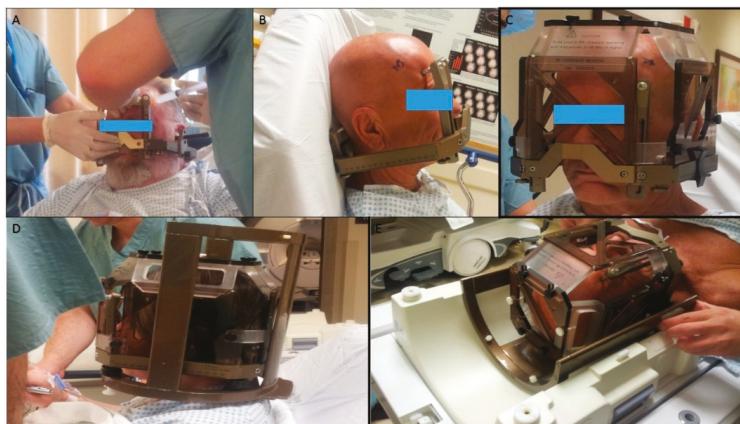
Different steps of Leksell frame application. (A) Application of the frame with the ear bars; note that the assistant is holding the frame in position with a lateral bar parallel to the intercommissural line while the senior surgeon is injecting a local anesthetic at the site of pin fixation; (B) position of the frame after its application; (C) the magnetic resonance imaging (MRI) localizer attached to the frame base; (D) the MRI localizer and the table adaptor attached to the frame base; (E) the table adaptor fitting to the MRI table.
